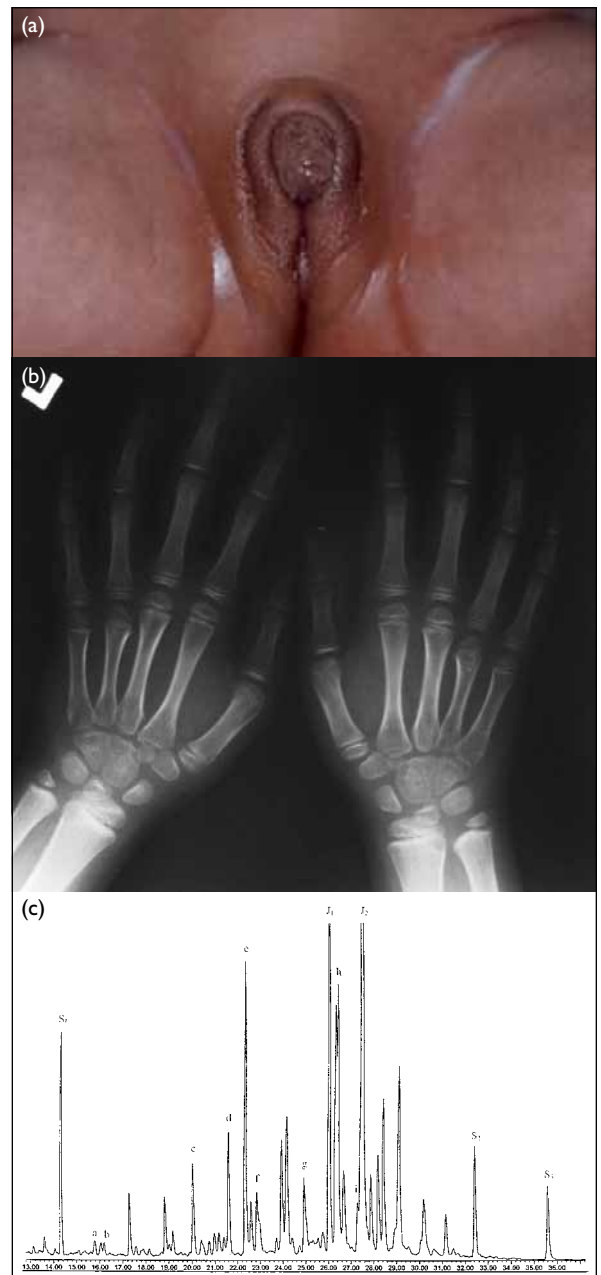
(a) External genitalia with clitoromegaly and complete labial fusions (virilisation) at birth. (b) Radiograph showing arachnodactyly. (c) Gas chromatogram of urinary steroid profiling of the patient
